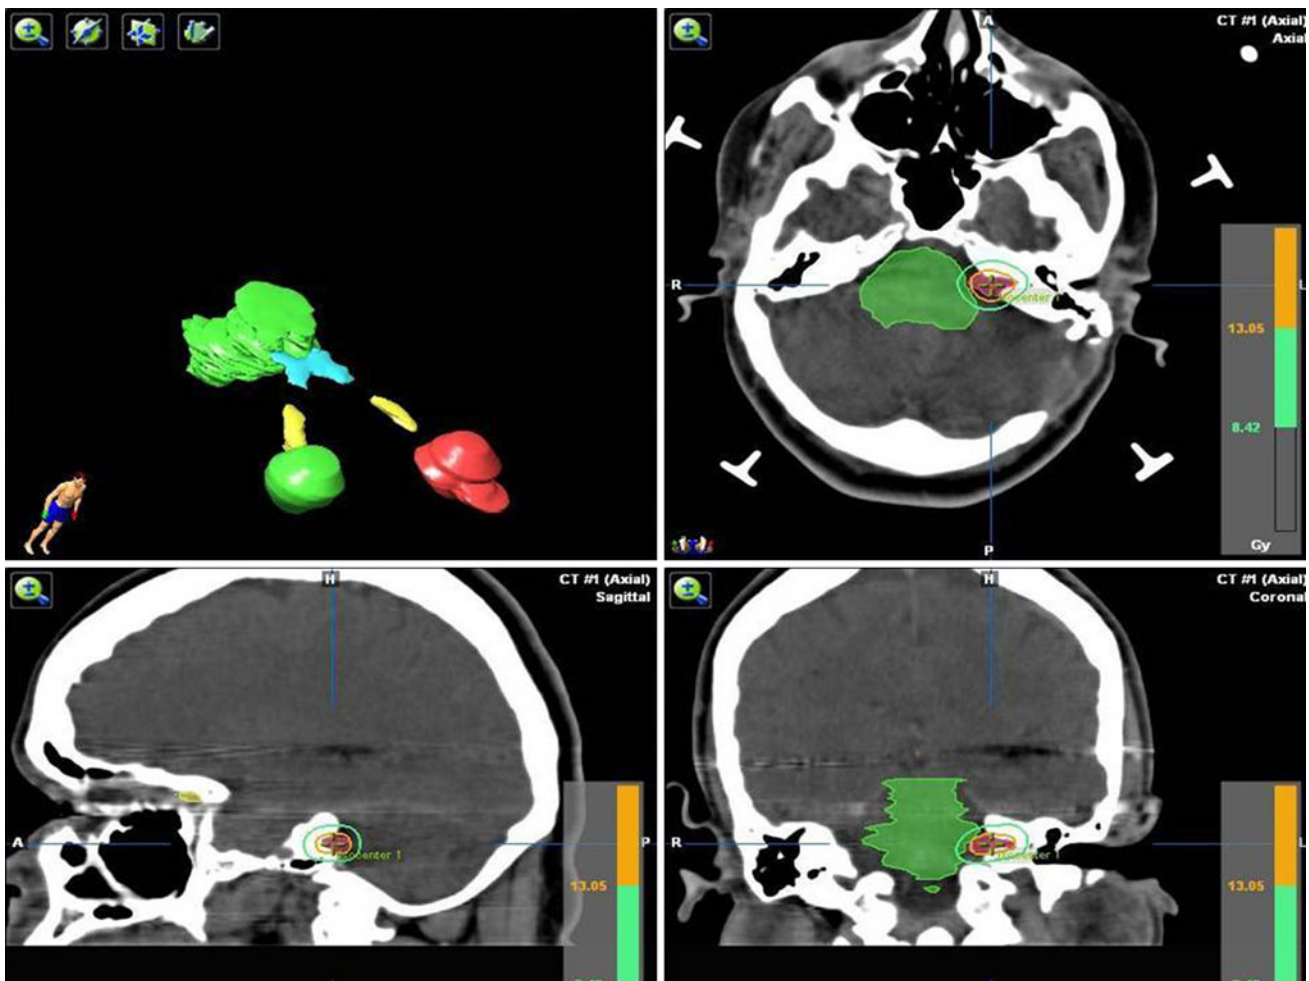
CT scan images showing dose distribution of AN patient planned with LA-based system (BrainLAB)
